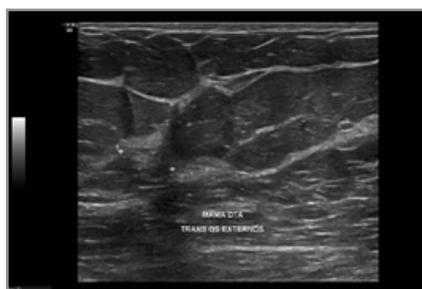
Ultrassonografia, Demonstrando O CDIS.
